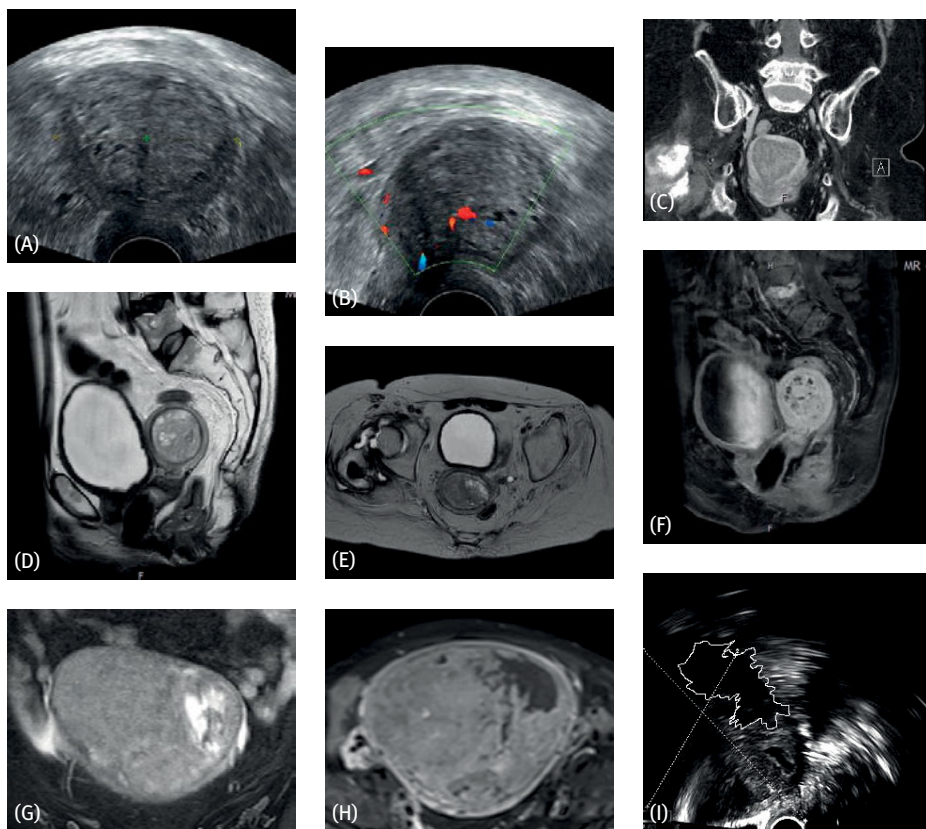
Sonography, CT and MRI of one identical patient with adenosarcoma without sarcomatous overgrowth and MRI of a patient with an adenosarcoma with sarcomatous overgrowth. (A) in axial gray scale sonography the uterine cavum is distended. As exemplified in the following CT (C) and MRI (D–F) images, the surrounding myometrium is rather visible, at least in the immediate vicinity of the transducer. The tumor has heterogeneous echogenicity. The margins between the areas with differing echogenicities are only barely visible, and appear to be irregular to bizarre. In this plane, the echo voids most likely correspond to central vessels with a visible narrow hyper-echoic border margin; (B) Doppler sonography reveals dilated vessels alongside anechoic voids, that most likely resemble dilated glands; (C) in contrast CT, the tumor generally shows a strong enhancement, but also contains areas with lower attenuation. The overall picture corresponds to the “lattice-” or “truss”-like structure described in the literature; (D), (E) the tumor is hyperintense to the myometrium in sagittal (D) and axial (E) T2W, and exhibits numerous areas of even greater SI that correlate to dilated glands; (F) the dilated glands do not enhance in contrast-MRI, thus serving to help secure a reliable diagnosis. All images clearly show that the margin or border to the myometrium is irregular, best exemplified by the fact that the hypointense margin is repeatedly interrupted in the MR images. The tumor has infiltrated the myometrium in these areas. Additionally, the protrusion of the tumor into the cervix is visible in (C) and (F); (G) in a case with sarcomatous overgrowth the tumor is heterogeneous hyperintense in T2W-MRI with a greater and only some small regions of high SI; (H) the greater and some small hyperintense regions do not enhance in contrast MRI. The large area corresponds to a necrosis, while the smaller sections correspond to glands; (I) in the corresponding sonography the outlined necrosis is also visible. In contrast to the findings in (C)–(E), in (G)–(I) the sarcoma share typically consists of a high-grade sarcoma with very few glands but extensive necrosis.
